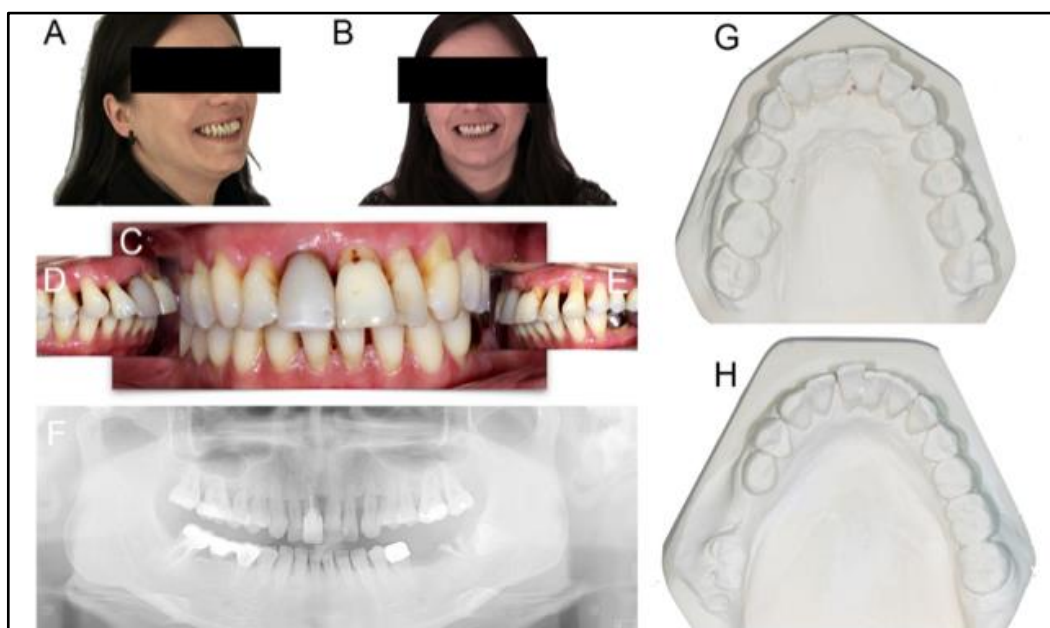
The diagnostic data set of the pre-operative clinical presentation of an example study patient. (A-E) clinical photographs (F) panoramic radiographic image, and (G, H) diagnostic casts.
